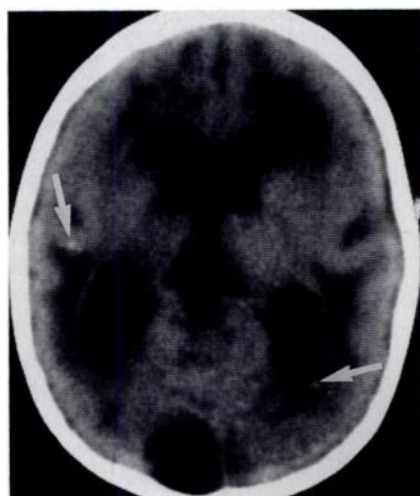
10-month-old child with developmental delay and microcephaly. Presumptive diagnosis was cytomegalovirus (CMV) encephalitis. Axial CT scan shows hydrocephalus, hypodensity, volume loss, and punctate calcifications (arrows) in a predominantly periventricular distribution. Most likely cause is intrauterine infection by *Toxoplasma*, rubella virus, CMV, or herpesvirus. Serum assays for rubella, toxoplasmosis, and herpes simplex were negative. It was not possible to test a child of this age for infection with CMV.
